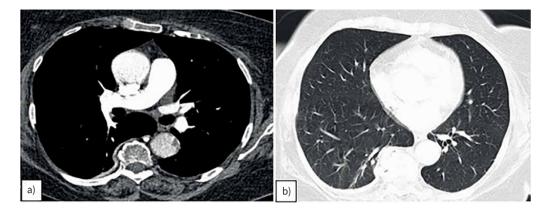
Computed tomography pulmonary angiography for patient 1. Axial images (1 mm slice thickness) showing a) no evidence of pulmonary embolism in a mediastinal window and b) no parenchymal abnormalities in a lung window.
